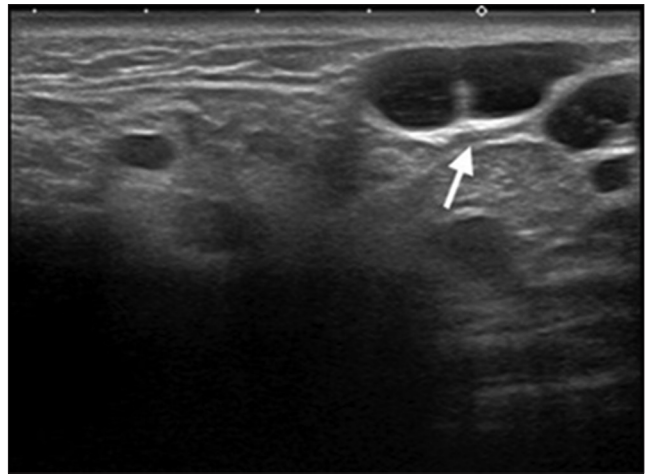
Transverse sonogram of the right upper neck revealed multiple matted, ovoid, hypoechoic, homogenous, and enlarged lymph nodes (arrow) below the right parotid gland
